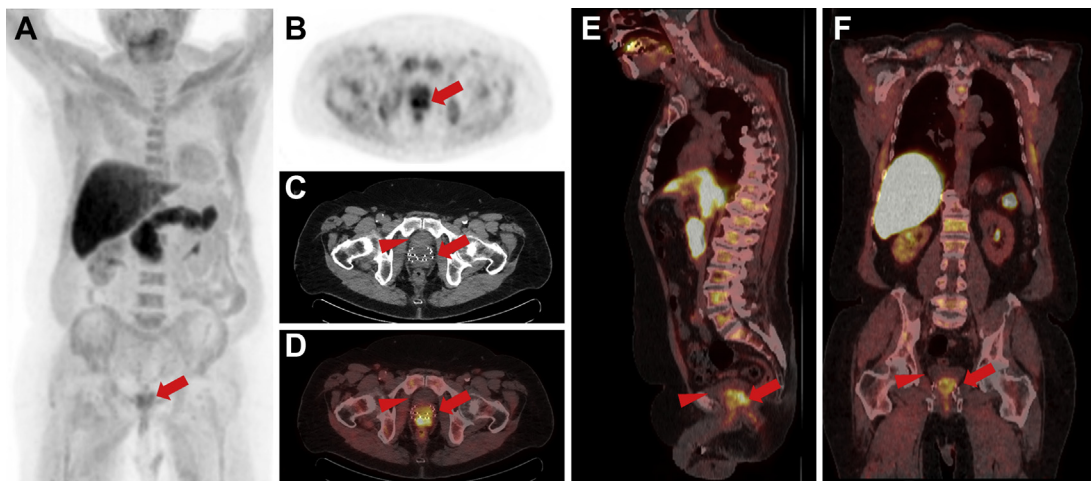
A 72-year-old man with biochemical recurrence of PCa with PSA 4 ng/mL after prior brachytherapy (initial PSA of 11 ng/mL). ^{18}F -fluciclovine PET/CT images (A) MIP, (B) axial PET, (C) axial CT, (D) axial PET/CT, (E) sagittal PET/CT (F), and coronal PET/CT images demonstrate increased tracer uptake within the prostate extending to the seminal vesicles (arrows). A prostate biopsy confirmed the presence of recurrent disease. Compared with ^{68}Ga -PSMA-11 or ^{18}F -PSMA-DCFPyL PET tracers, ^{18}F -fluciclovine urine washout to the bladder is usually mild (arrowheads), improving the evaluation of local recurrence.
